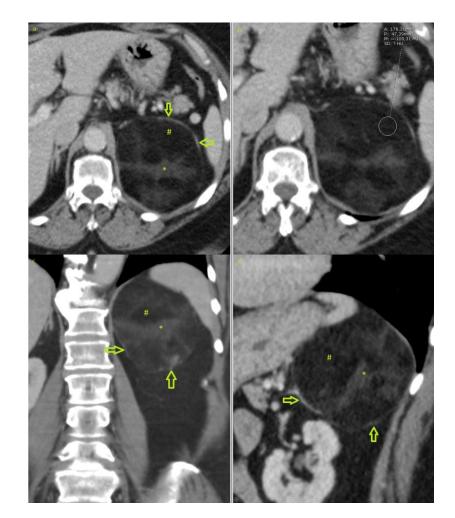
(comparative case) 68-year-old female with left adrenal myelolipoma. Contrast enhanced CT of the abdomen in a venous phase showing a well-circumscribed mass in the region of the left adrenal gland measuring 86x99x95mm. The mass is composed of fat cells (#) with density of -109 HU(b) and myeloid tissue with relatively higher attenuation. The mass shows a pseudocapsule (arrows in a, c &d). No infiltration of the neighboring structures. (Technique: 16-MDCT scanner. Automatic tube current modulation ranging between 300 and 440 mA, 120 KVp, 5mm slice thickness. Soft tissue window, level/width: 40/400. i.v. injection of 100 ml Imeron 300. Coronal and sagittal reformated CT with 5mm slice thickness. a) &b) axial planes, c) coronal reformation and d) sagittal reformation).
